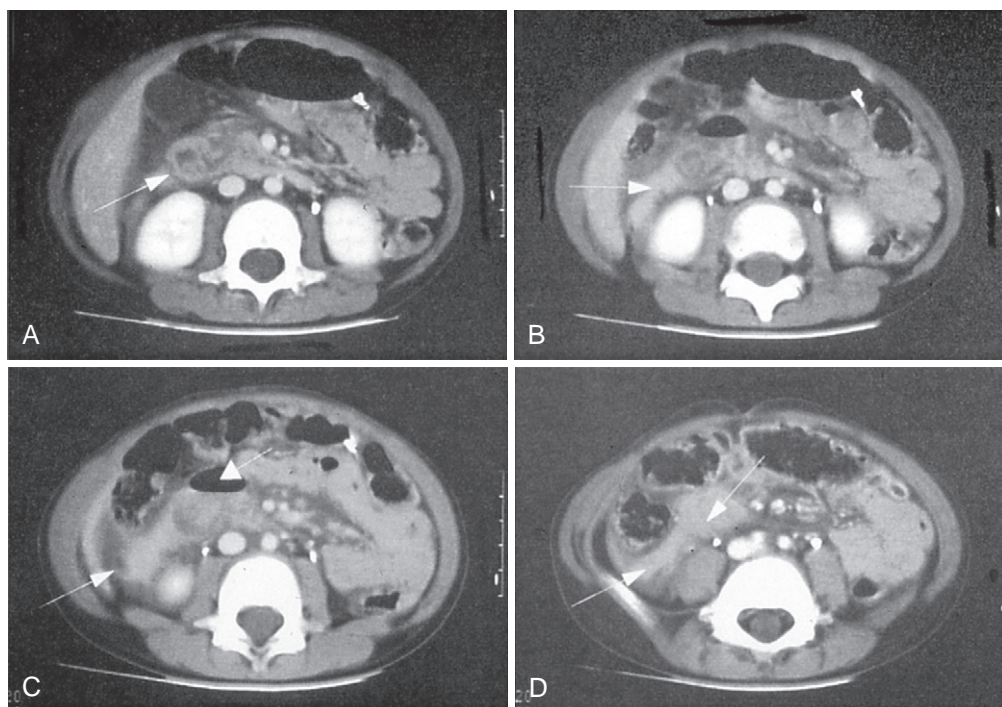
Abdominal computed tomography findings in a 4-year-old boy with duodenal perforation caused by a motor vehicle accident. A, The arrow points to the disrupted duodenal wall. B to D, Arrows point to extravasated retroperitoneal enteral contrast and extraluminal retroperitoneal air. A large defect involving the second and third portions of the duodenum was found. Primary repair, pyloric exclusion, tube duodenostomy, and gastrojejunostomy were performed. The child resumed eating 5 days after injury and went home 4 days later.
